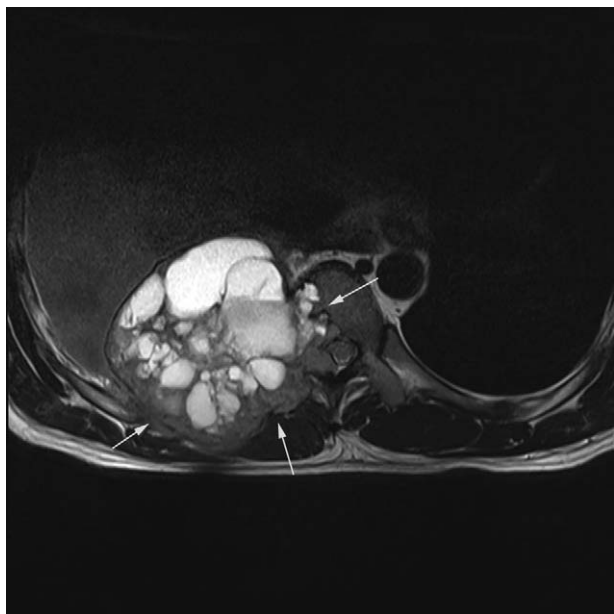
Axial T2-weighted image shows a large, irregular mass in the vertebral and accessories (arrow heads); the lesion contains multiple fluid–fluid levels.
